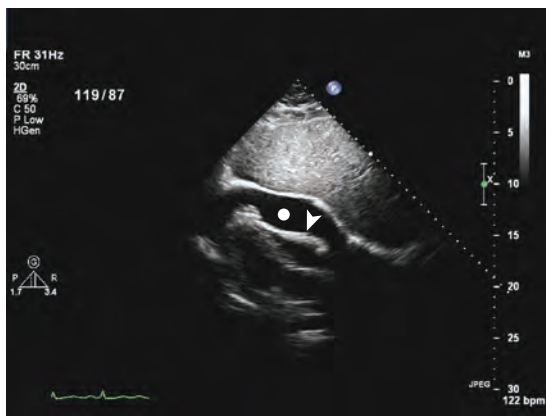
Cardiac tamponade. Subcostal transthoracic view with the liver is seen at the apex of the image. The large echolucent space in the pericardium (white dot) is acute accumulation of fluid. Note the collapse of the right side of the heart (arrowhead) during diastole. This patient underwent urgent pericardiocentesis under the guidance of echocardiography.
